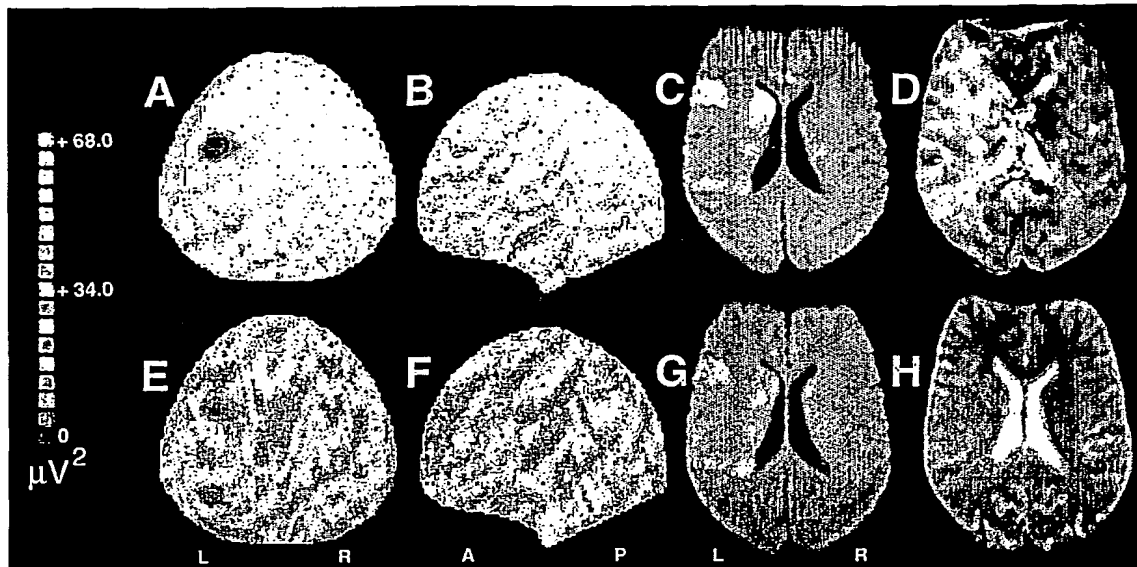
EEG and MRI data from a patient who made an excellent early recovery. A and B: Axial and left lateral EEG scalp Delta Power Maps (DPM) acquired 6.5 hours after onset of symptoms; C: initial DWI (6 hours); D: initial MTT map; E and F Axial and lateral DPM at 13 hours; G: 15 hour DWI scan and H: 30 day T2 MRI.
